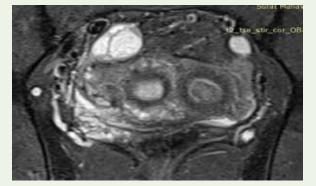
MRI STIR coronal image showing hyper intense lesion with internal hypo intensity seen on the left lateral aspect of the anterior myometrium.
